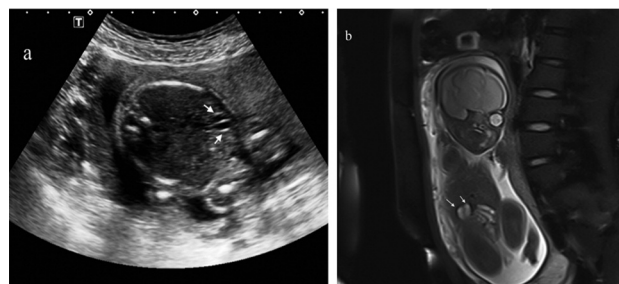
(a) Axial section of fetal abdomen on sonography shows two hypoechoic cyst-like structures (arrows, fetal gallbladder duplication). (b) Coronal T2 weighed MRI shows two rectangular cyst-like structure located at the lower border of the liver (arrows, fetal gallbladder duplication) at 26 weeks' of pregnancy.
